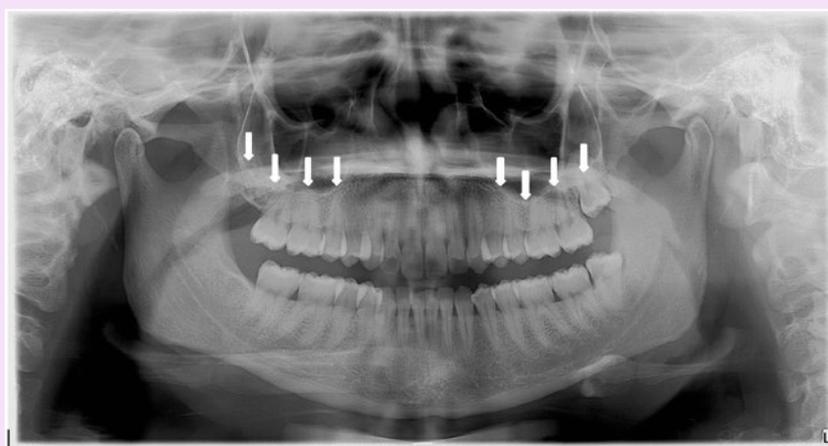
The intact maxillary sinus floor appears as a well-defined, uninterrupted radiopaque line (identified bilaterally by white arrows) on the panoramic radiograph. The adjacent healthy maxillary sinuses are radiolucent due to their air content
